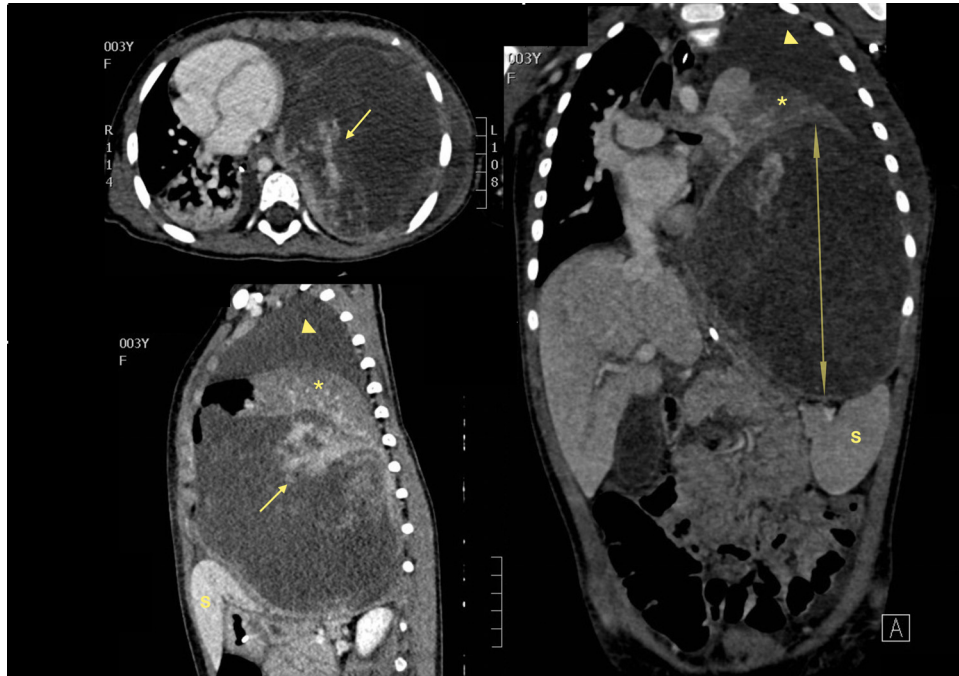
Chest CT showed a solid-cystic mass lesion with inhomogeneous enhancement filling almost the entire left hemithorax and displacing the mediastinum to the right side (double arrow). The mass extended upon the left hemidiaphragm displacing the spleen (S) and the left kidney inferiorly. Solid portion was localized mainly along the postero-superior profile of the lesion (arrow). Cystic spaces were fluid-filled without air-fluid levels. Residual left lung was normal and totally compressed (*). Massive left pleural effusion was also seen (head of arrow)
